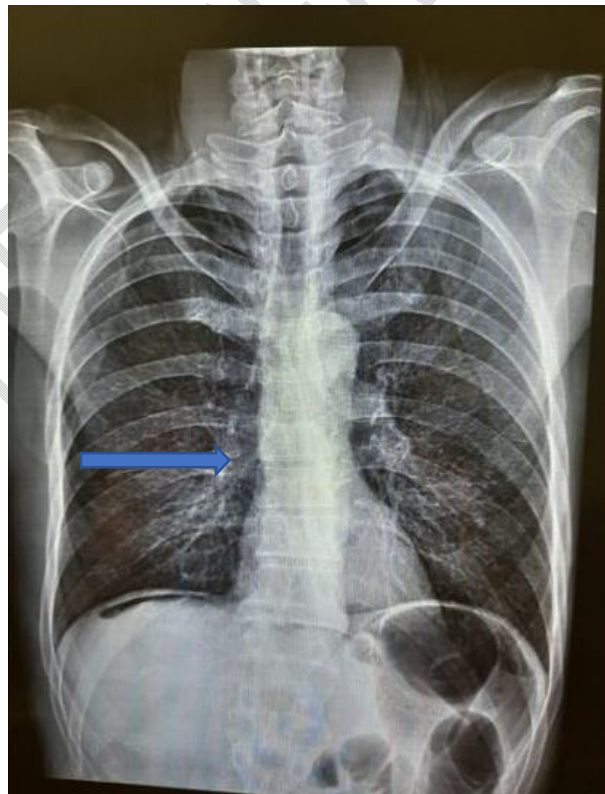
The chest X-ray showing pneumoperitoneum
